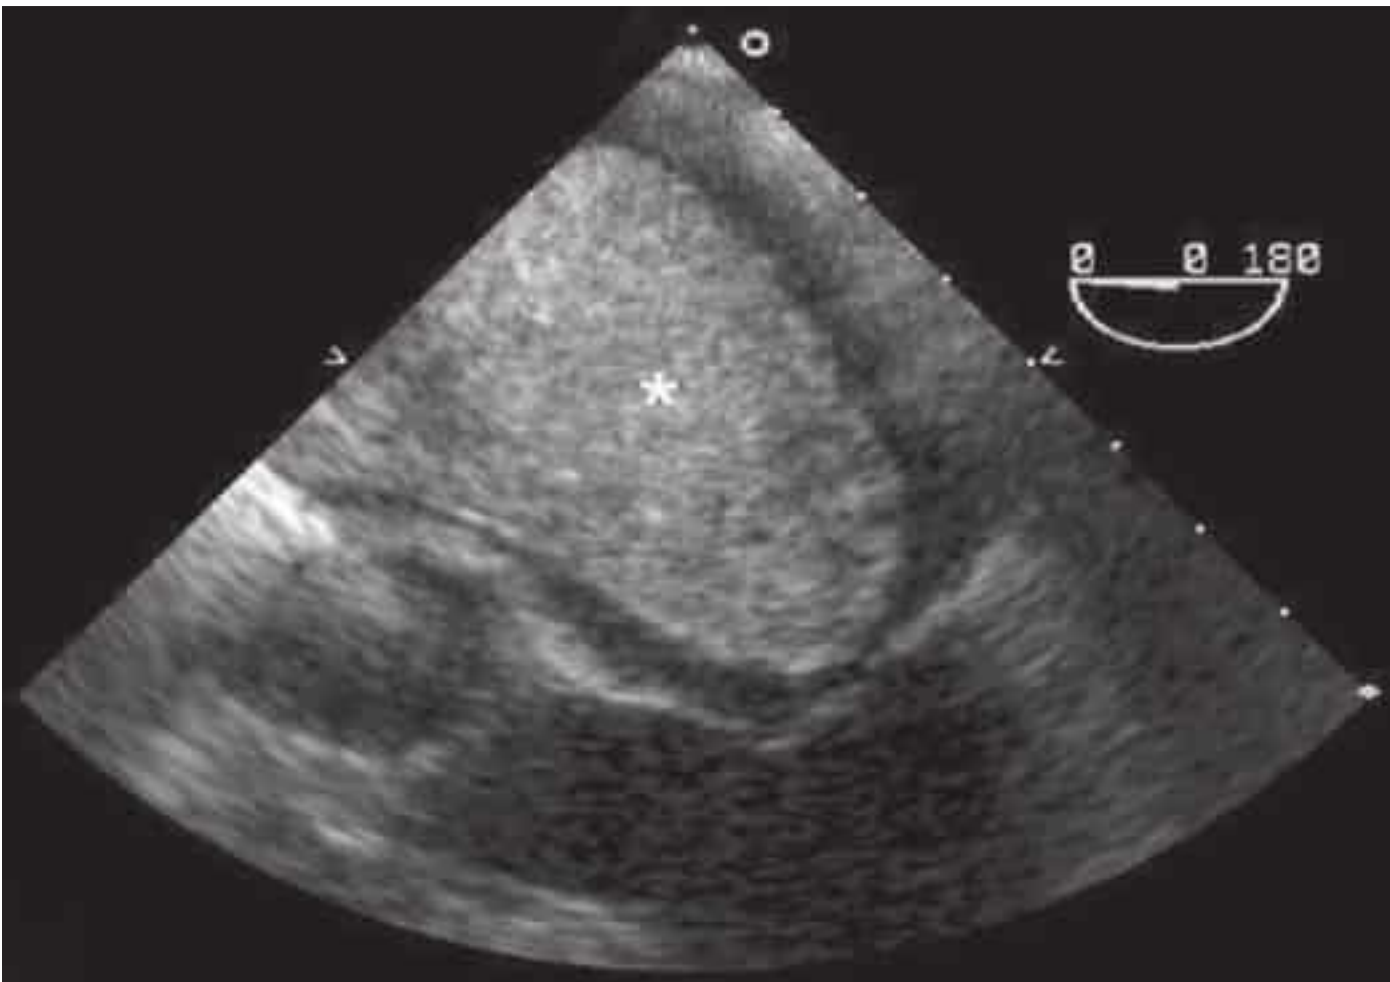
Echocardiogram of a giant myxoma (asterisk) that occupies almost the entire left atrium.
